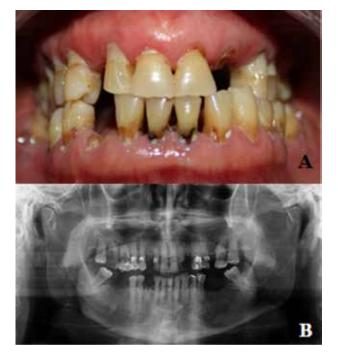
a) Intra-oral image of the patient b) Panoramic radiograph showing dental patient's condition
